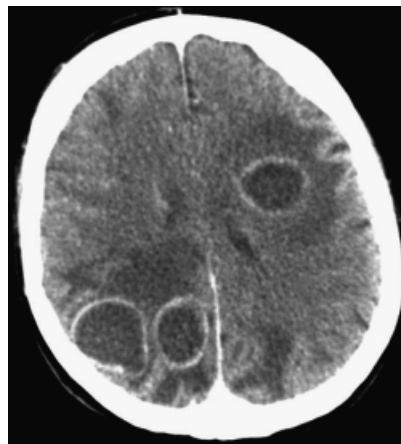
Computed tomogram brain. Abscesses visible in right and left cerebrum.
